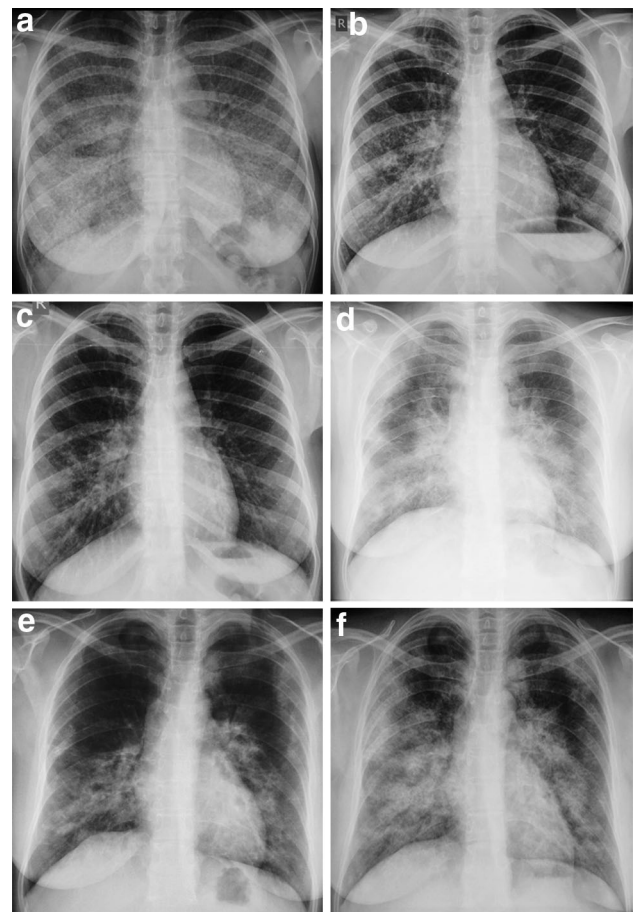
Radiographic images of the chest of two of the six patients treated with inhaled granulocyte macrophage–colony-stimulating factor (iGM-CSF) at three different timepoints: before treatment, at the time of disease remission, and on the last (current) measurement. Images are considered representative of all patients. a–c Correspond to patient No. 3, who remains in remission and d–f correspond to patient No. 5, who developed disease relapse after the second diminution of the initial iGM-CSF dose
